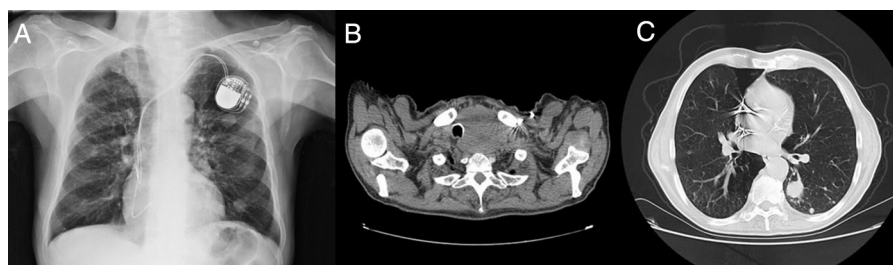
(A) Chest radiography showing right tracheal deviation. (B) Neck CT demonstrating right tracheal deviation due to thyroid enlargement. (C) Chest CT with multiple lung nodules.
